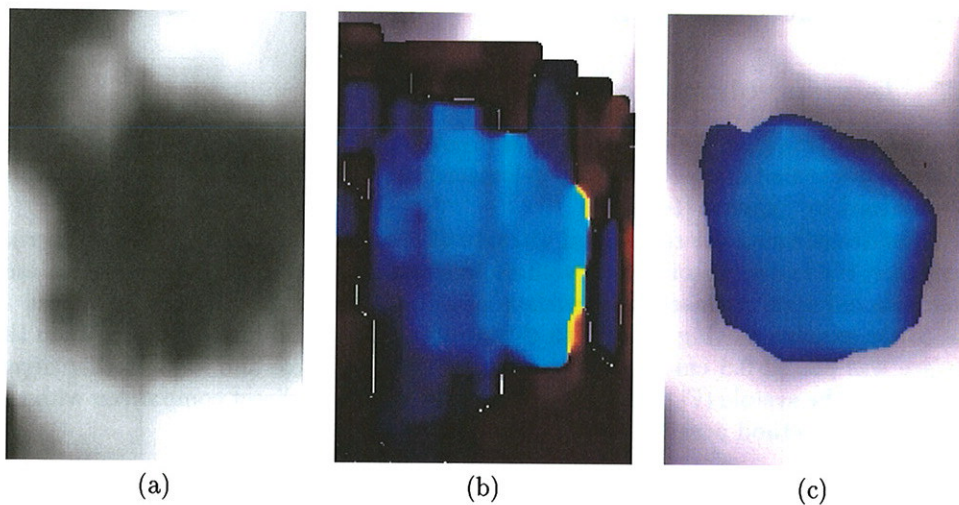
One slice through the 3D data in the distal LVOT during the aortic outflow in systole. (a) The raw tissue data. (b) The corresponding raw Doppler values. The negative velocities (away from the probe) are coded in blue. The red and dark colors are positive velocities (towards the probe). (c) Combination of the filtered, separate tissue and Doppler values. Note that the colors represent the velocity vector components perpendicular to the image plane.
